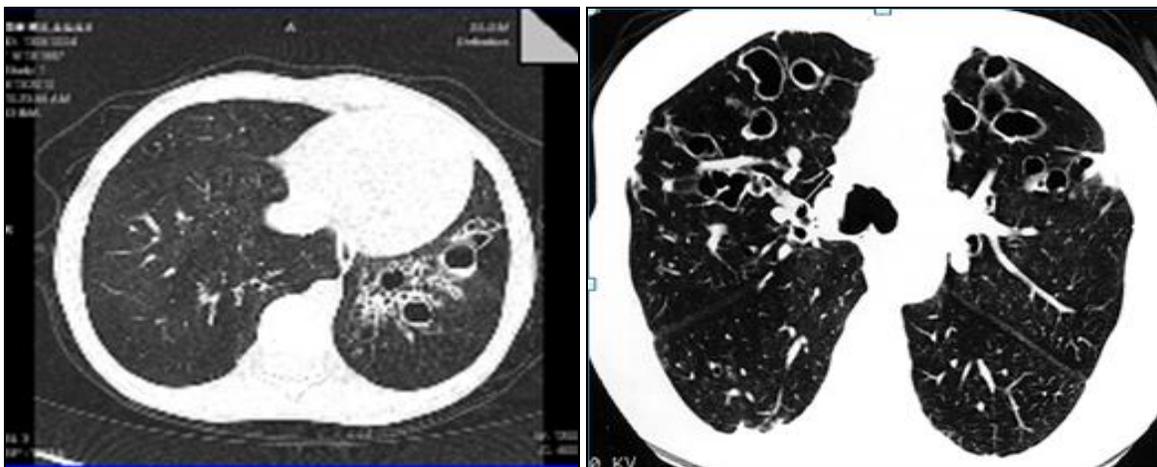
CT scan image: A) a cystic bronchiectasis in the left lower lobe B) cystic bronchiectasis in anterior distribution in both tow lungs
